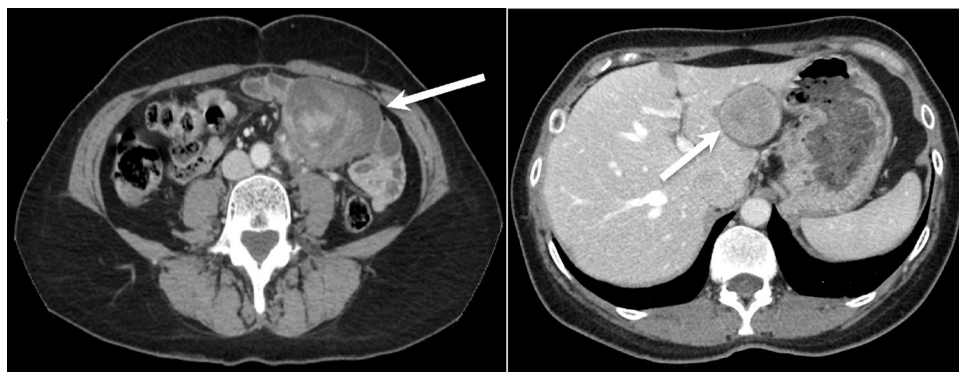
Computed tomography: Left panel, mesenteric mass with mixed hyper- and hypo- attenuating areas on arterial phase imaging; Right panel: similar appearing lesion in segment II liver.
